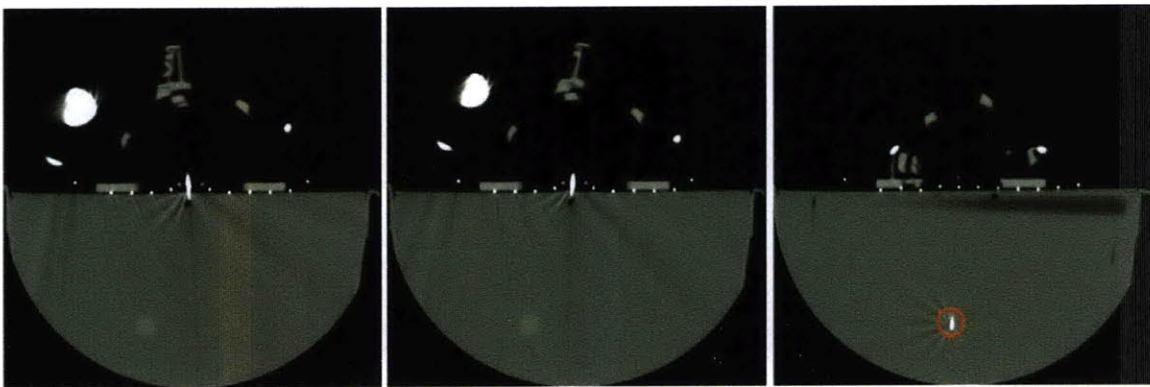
CT scans from one of the targeting experiments. Left, initial orientation of needle. Middle, needle aligned towards target (not visible in this plane). Right, needle placed in target.
